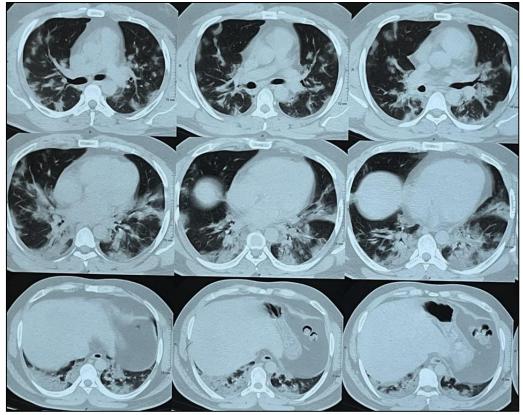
HRCT thorax showing multifocal, ill-defined to well defined consolidation with line of demarcation in bilateral lower lobes. Pleural based and central patchy consolidations in bilateral middle lobes with few GGOs
